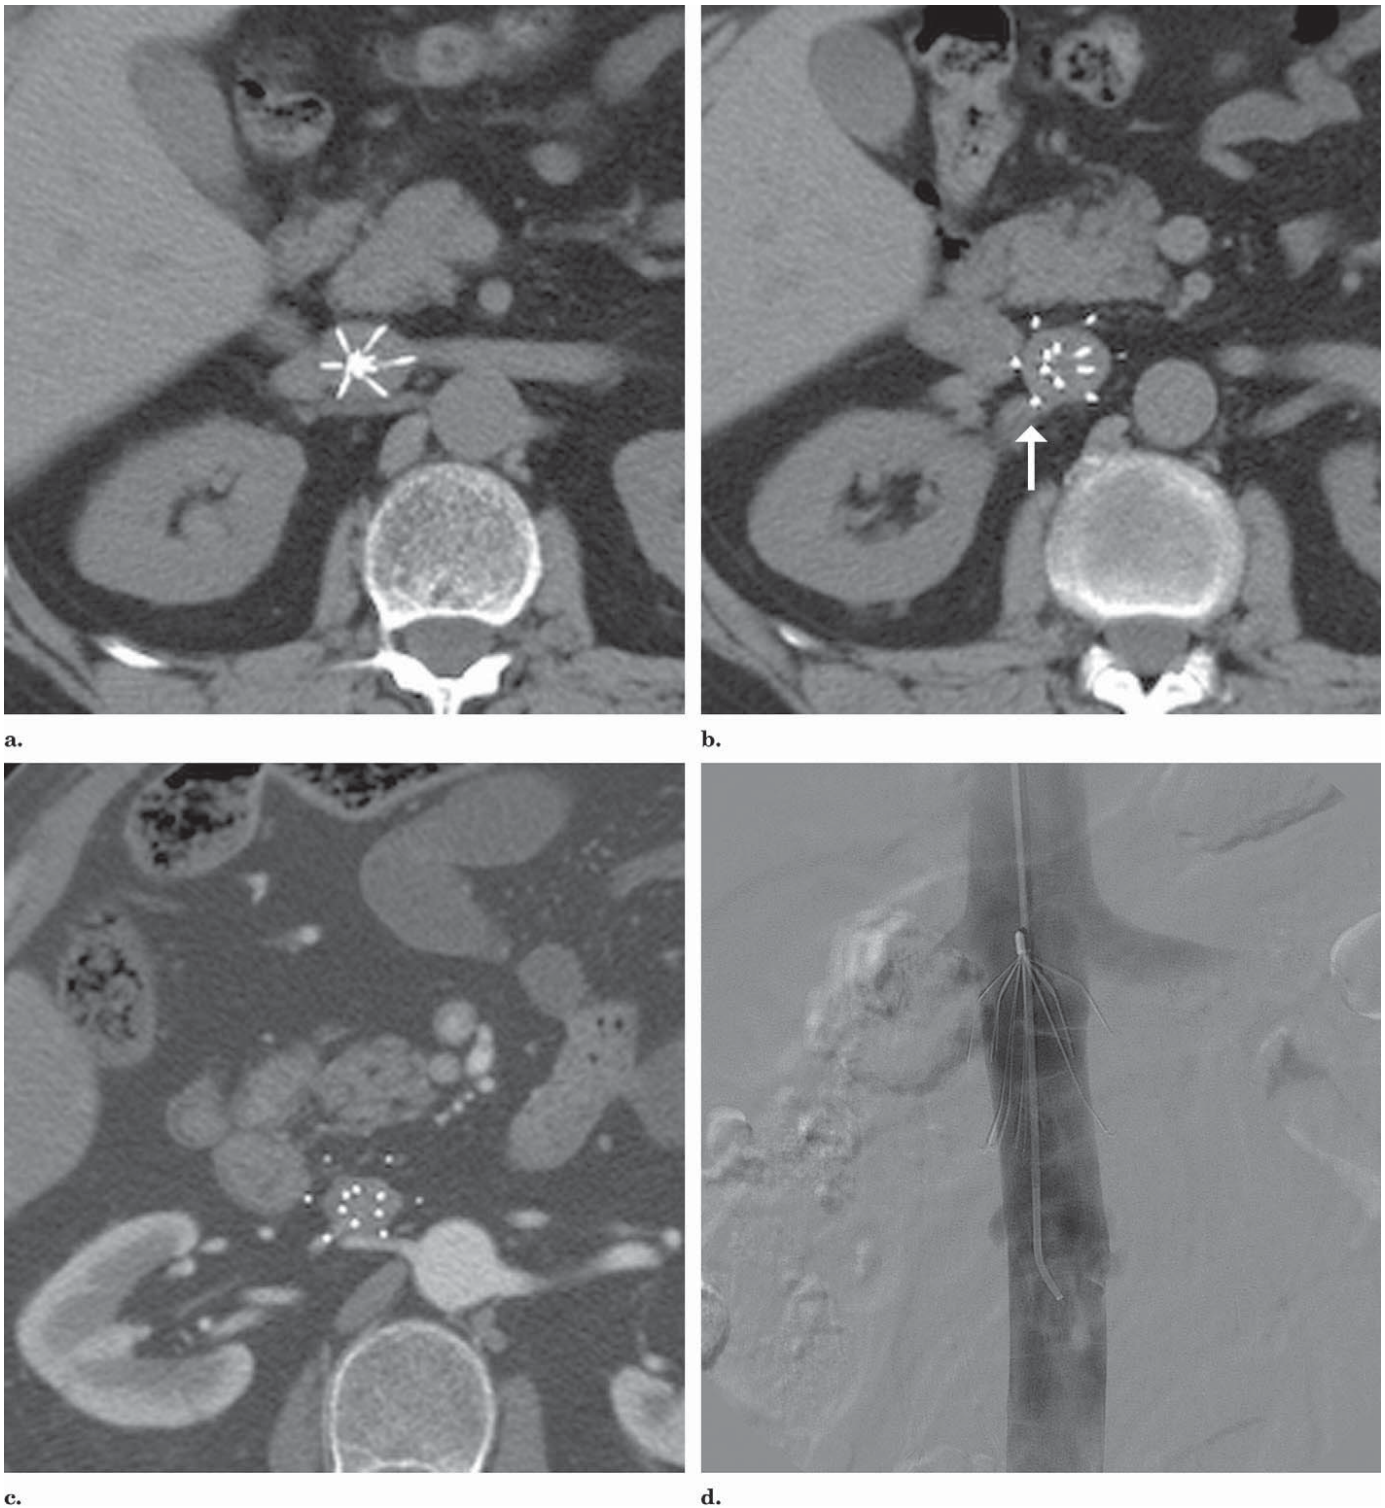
Appearance of perforated arms on CT and inferior vena cavogram. The Recovery filter has six arms and six legs. (a) Intact top of the filter with six arms. On images (b), note that all the arms are outside the IVC. Several of the arms are completely surrounded by fat. The arm at 7 o'clock (white arrow) appears to be in a small vein. The six legs are in the center of IVC and none of the legs have perforated the IVC. (c) On an image taken caudal to b, the tips of only four arms are noted. Arms at 5 and 7 o'clock are adjacent to but outside the IVC (note acute angle between arm and IVC wall), and these were counted as perforations. (d) Anteroposterior view of the IVC shows the arms on either side to be well outside the IVC.
